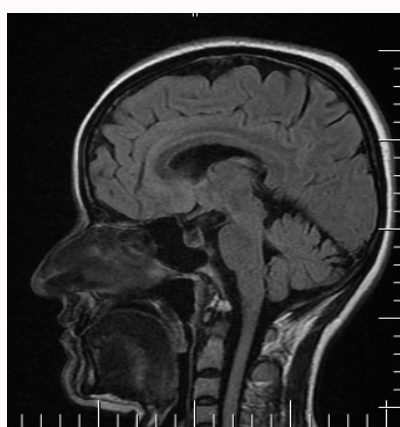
FLAIR-contrast-enhanced cranial MRI sequences dated 24/08/2020.
